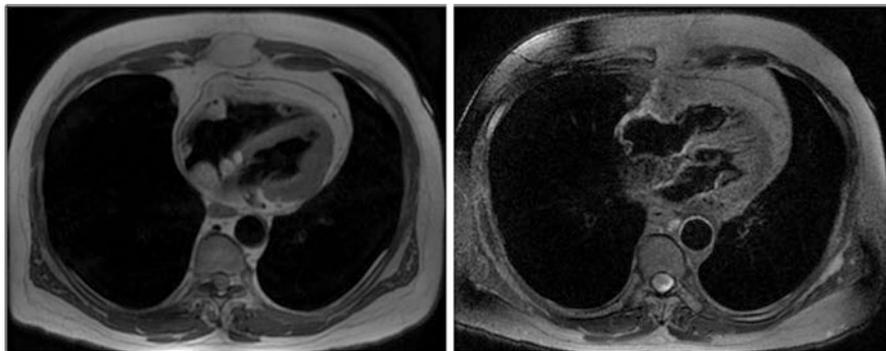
Mediastinal lipoma. Biopsy-proven lipoma of the mediastinum and the pericardium. *Left panel:* gradient-echo T1-weighted MRI sequence; *right panel:* T2-weighted MRI sequence
